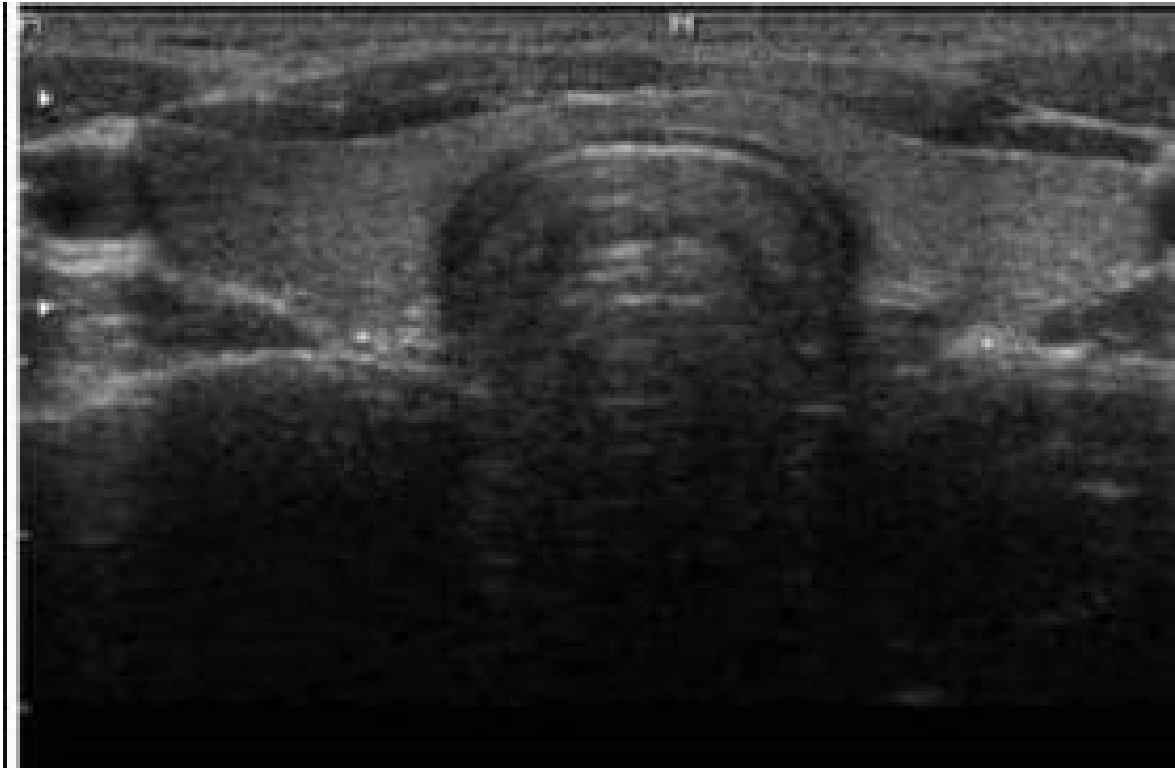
Ultrasound examination of the Hypothyroidism a 29-year-old woman showing homogeneous in texture.
